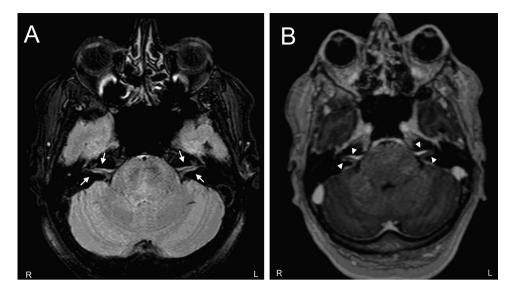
Magnetic resonance imaging (MRI) findings in a patient with intracranial hypotension (IH). Axial SPAIR image passing through the IAC shows linear hyperintense signal within the bilateral IAC indicative of subdural effusion (white arrows, A). Post-contrast axial reformatted 3D T1-weighted image passing through the IAC shows linear enhancement along the walls of the IAC bilaterally (white triangles, B).
